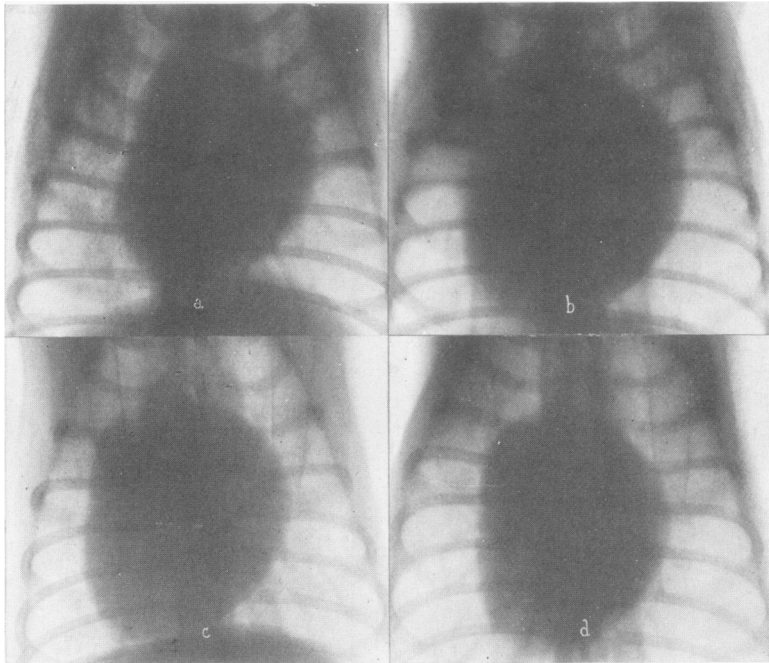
ROENTGENOGRAMS OF EXPERIMENT 4
